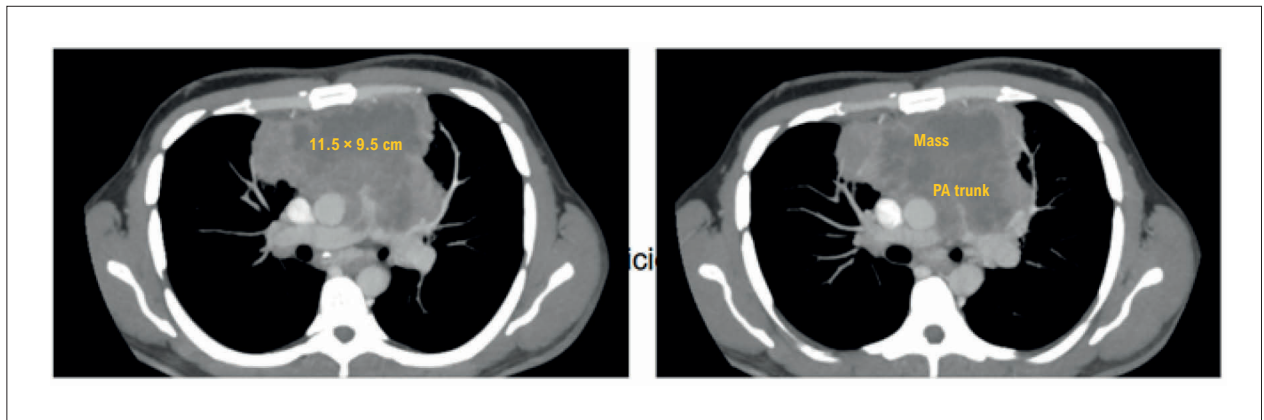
Chest computed tomography angiography showing the mediastinal mass. PA: pulmonary artery.
